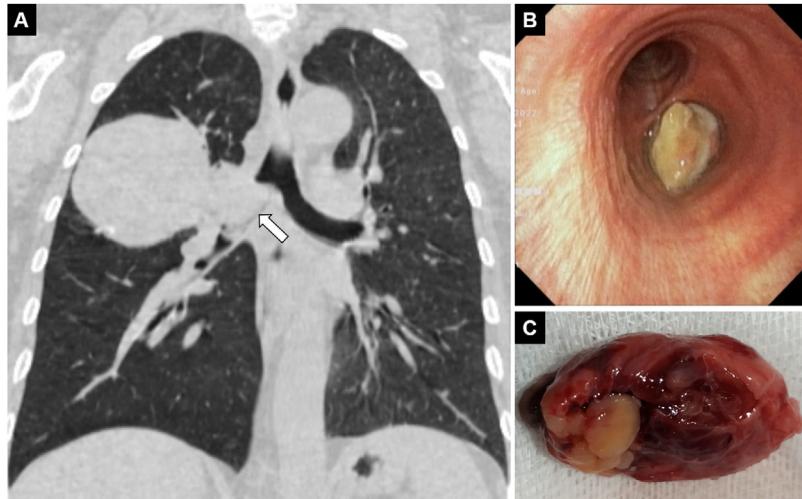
Coronal thoracic CT section (A) shows a 110 mm × 80 mm solid mass lesion located in the right hilar and invading the main bronchus (arrow). Flexible bronchoscopy shows a polypoid type endobronchial lesion protruding from the right main bronchus entrance to the trachea (B). Spontaneously expectorated tumor tissue of 33 mm × 20 mm × 14 mm is seen macroscopically (C).
